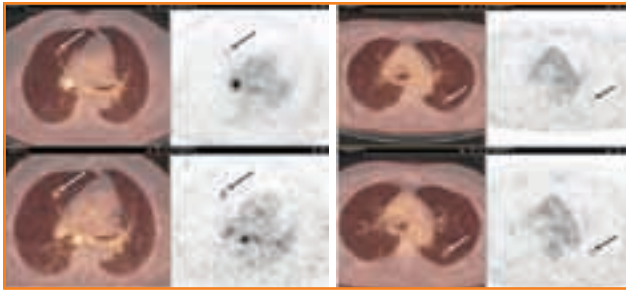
Comparison of ungated (top) and respiratory-gated (bottom) PET/CT images of small pulmonary lesions. (Source: Moinuddin A, et al.¹⁰)
